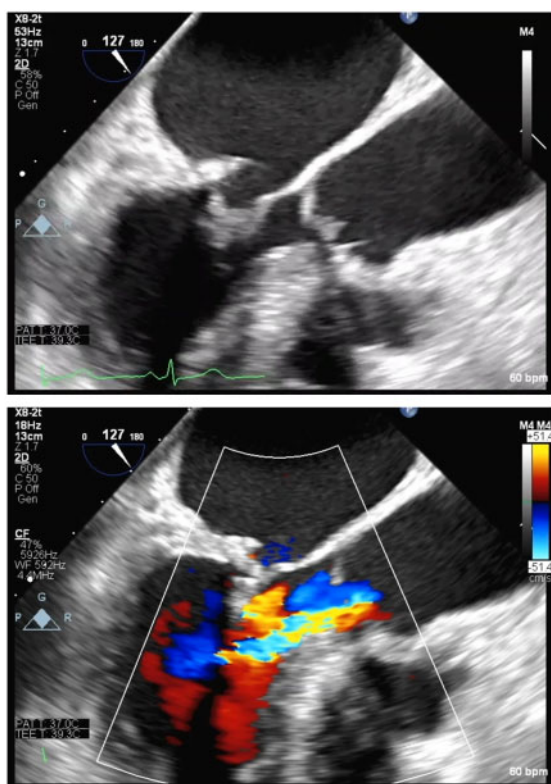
Post-MitraClip transoesophageal echocardiographic images demonstrated displacement of the leaflets' coaptation point towards the left ventricular inflow with resolution of systolic anterior motion (A) and decreased mitral regurgitation to mild (B). Three-dimensional mitral valve viewed from the left atrium (C) and left ventricle (D) in diastole showing a single NTR (arrowheads) deployed at the medial portion. A pulse wave Doppler trace through the left ventricular outflow tract showing the decreased peak velocity of left ventricular outflow tract to 1.7 m/s (E). A continuous wave Doppler trace through the mitral valve showing the slightly increased transmitral pressure gradient to 5.1 mmHg (F).
